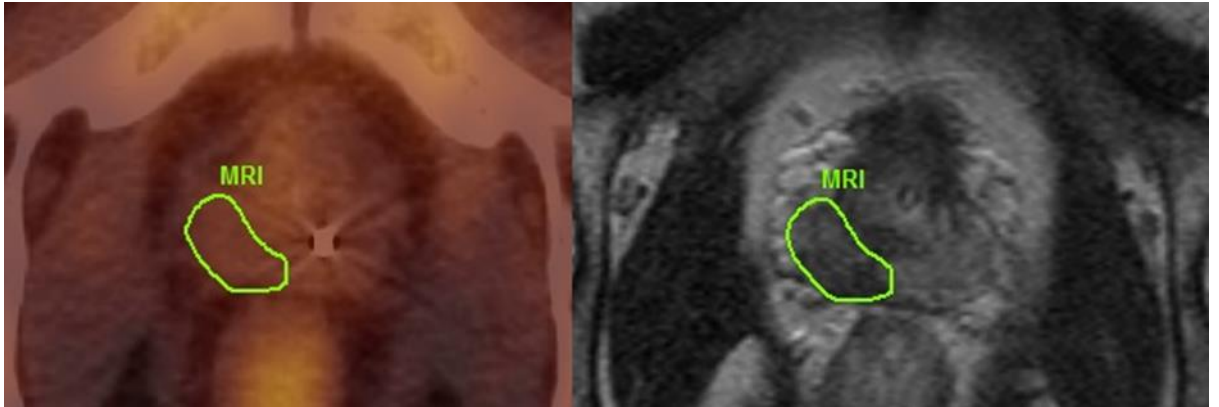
Example of a patient who had PET/CT (left) with bicalutamide. The DIL identified visually by PET is smaller than the corresponding DIL identified by MRI (right).
